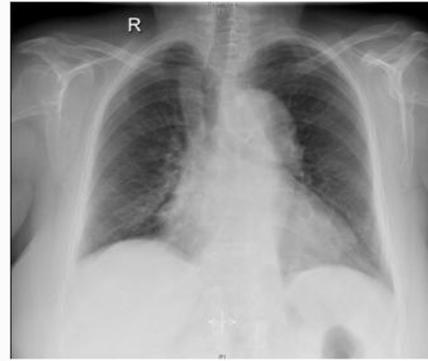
Chest radiograph showing absence of foci of infection.
